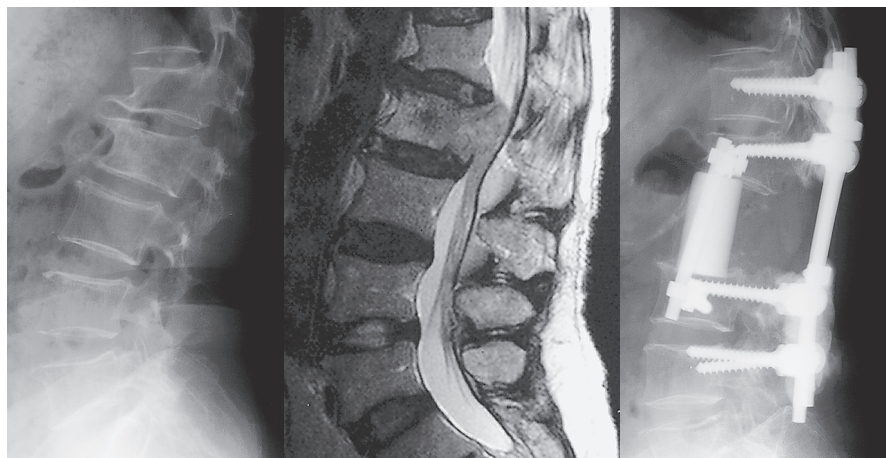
68-year-old woman with thyroid cancer. Preoperative CT and MRI show metastatic L2 tumor, arising from thyroid cancer. Second lumbar spine collapse and dural tube compression were imaged. En bloc spondylectomy of L2 was performed according to Tomita's technique.
